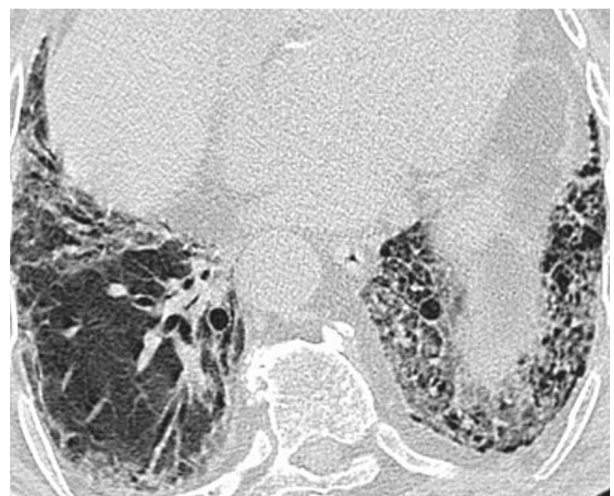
Post-COVID 14th month CT scan honeycombing and traction bronchiectasis at bilateral lower lobes
